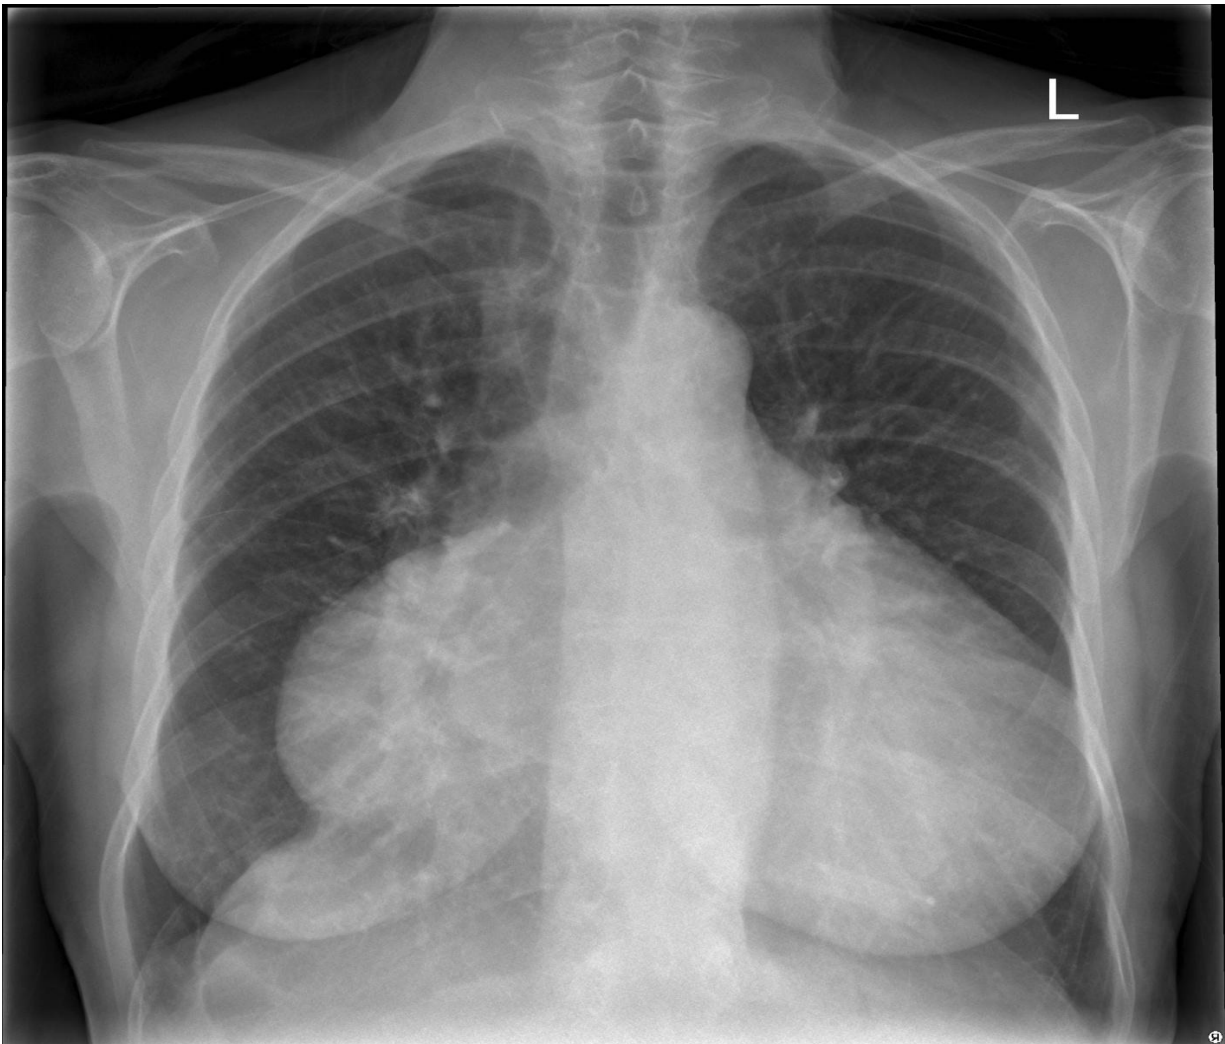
Chest radiograph- massive cardiomegaly with marked enlargement of both atrium and right ventricle
